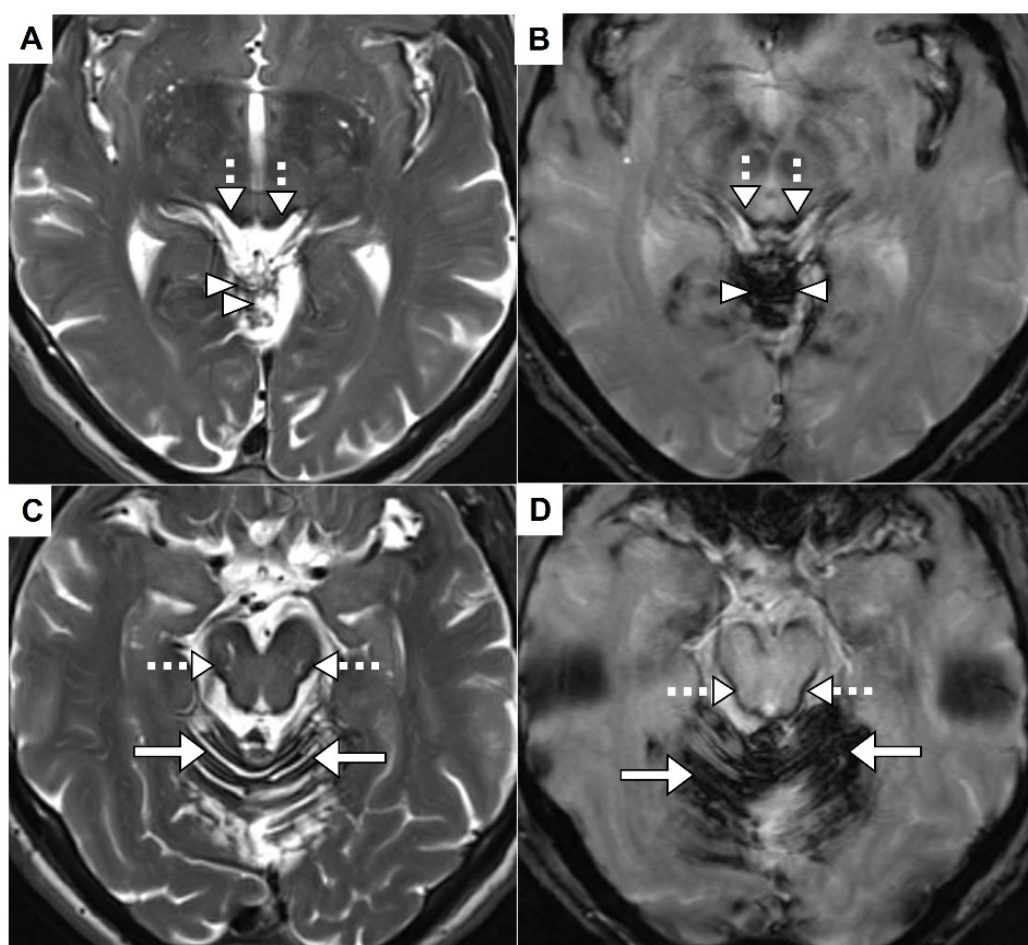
Axial T2-weighted (A, C) and corresponding susceptibility-weighted (B, D) MR images of haemosiderin appearances, demonstrating characteristic signal loss consistent with haemosiderin deposits involving superior vermis (arrowheads, A, B), cerebellar folia (solid arrows, C, D) and midbrain (dashed arrows, A-D). Figure reproduced under the Creative Commons CC-BY 4.0 International licence, from Kharytaniuk et al (Neurology, 2022) (74).
